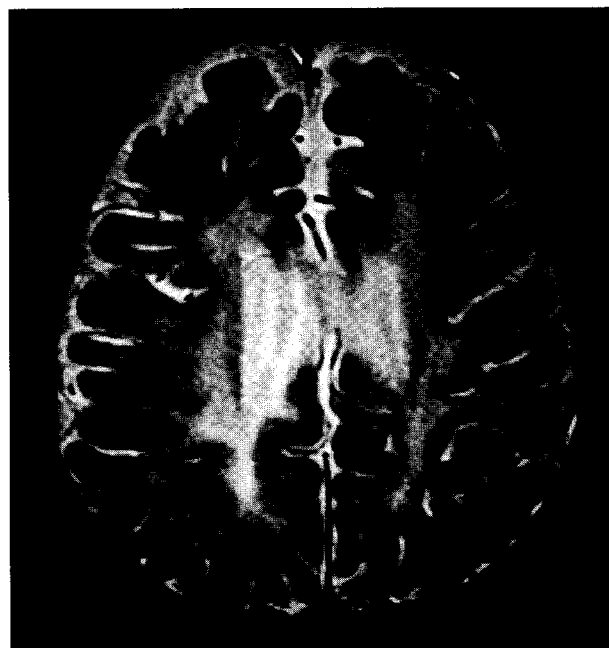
Magnetic resonance imaging scan of patient 1 (echo time, 80 milliseconds; repetition time, 2200 milliseconds) shows an abnormal, diffuse increase of signal from subcortical and periventricular white matter.
